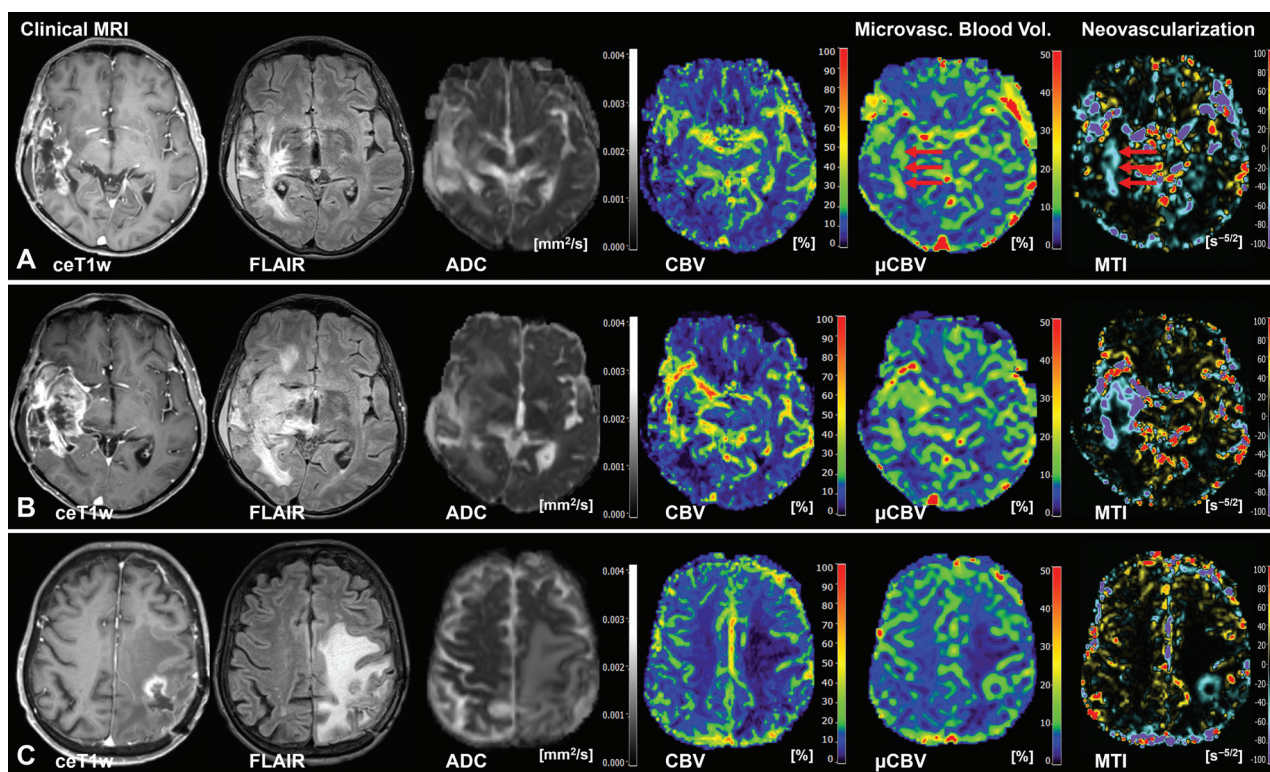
Early TP detection of glioma recurrence with μ Perf and FN findings in cMRI. A, cMRI including anatomic sequences (ceT1w and FLAIR), diffusion-weighted (ADC), and macrovascular perfusion (CBV) MRI as well as μ Perf biomarker maps of μ CBV and neovascularization (MTI) of a 66-year-old female patient with a GBM who was diagnosed with "posttherapeutic effects, no signs of recurrence" in cMRI due to lack of macrovascular hyperperfusion in CBV. μ Perf data, however, showed evidence of recurrence (red arrows), ie, microvascular hyperperfusion in μ CBV and an indication of neovascularization in MTI at the initial follow-up examination. B, At the subsequent follow-up examination 67 days later the patient shows clear signs of recurrence in cMRI data, and progression of the recurrent GBM in μ Perf data. The tumor volume had increased 14-fold, from 6.8 to 102.1 cm³ within the 67 days. The patient received bevacizumab as second-line monotherapy due to clinically confirmed tumor progression. C, cMRI and μ Perf biomarker maps of a 68-year-old male patient with GBM (WHO grade 4, *IDH* wild-type). The cMRI data were classified as radiation necrosis and pseudoprogression due to lack of macrovascular hyperperfusion in CBV. Signs of increased microperfusion and neovascularization are clearly visible. Despite negative cMRI findings, the treating physician initiated therapy with bevacizumab. Microvasc. indicates microvascular; Vol., volume.
